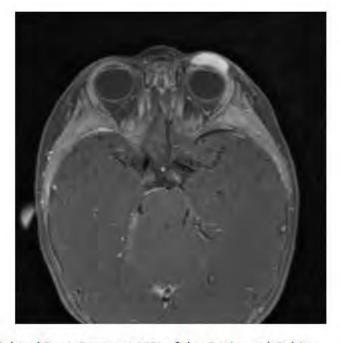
Axial T1-Weighted Post-Contrast MRI of the Brain and Orbits.
